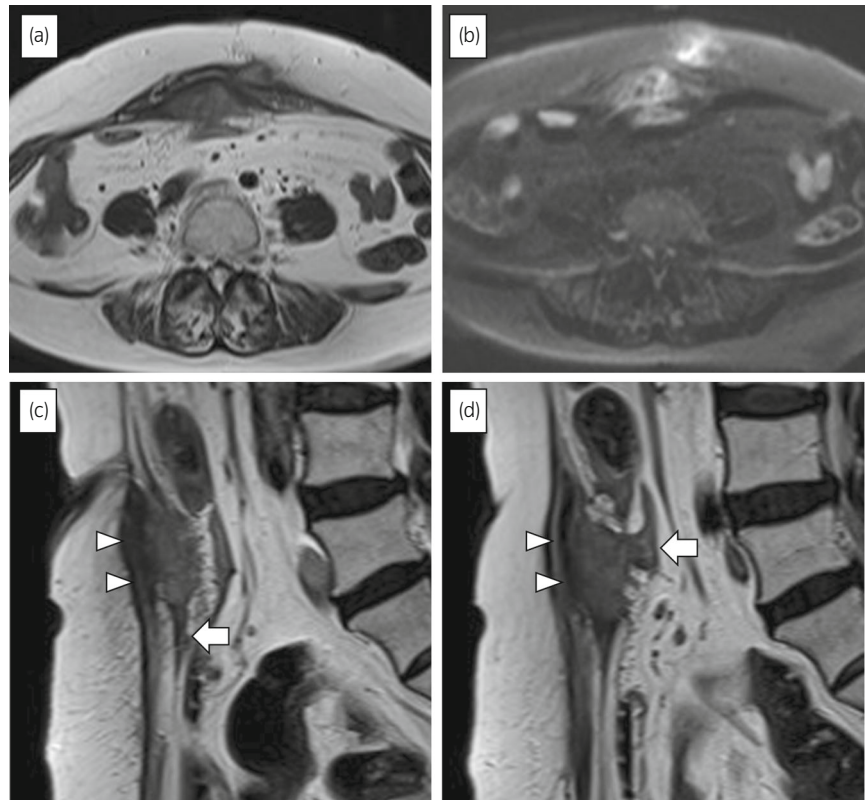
Magnetic resonance images of the abdominal wall mass suspected to be a urachal carcinoma. (a) Axial T2-weighted and (b) axial diffusion-weighted images of the abdominal wall mass. Median ADC value within the tumor was $1.16 \times 10^3 \text{ mm}^2/\text{sec}$. (c) Sagittal T2-weighted image revealing the mass (arrowheads) connected to the urachus (arrow). (d) Sagittal T2-weighted image showing the mass (arrowheads) invading the small intestine (arrow).
